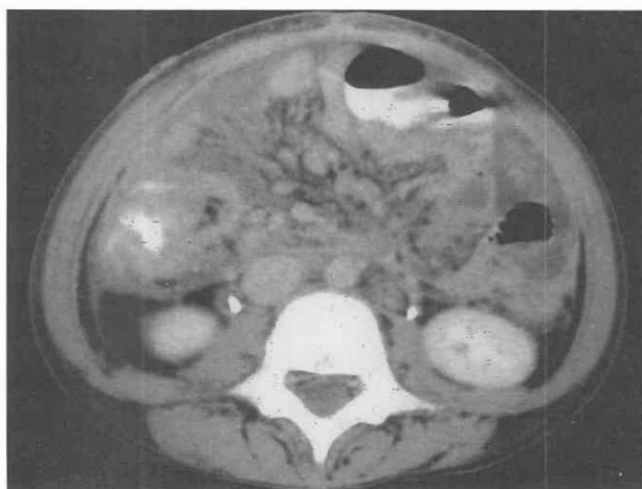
Adenocarcinoma of the colon. CT scan through the lower abdomen of an adolescent patient demonstrates irregular thickening of the ascending colon with luminal narrowing and associated mesenteric lymphadenopathy. At surgery, adenocarcinoma of the colon was noted.
